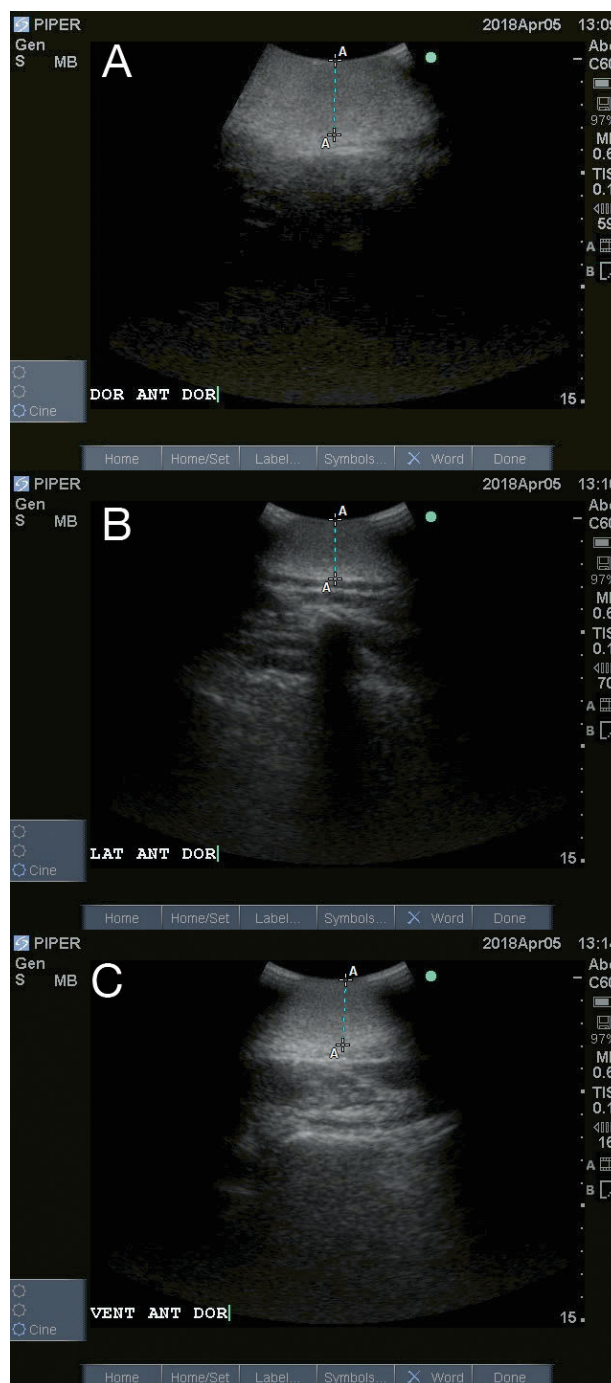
Three ultrasound images taken along the anterior dorsal fin girth location, (A) mid-dorsal (DOR ANT DOR), (B) mid-lateral (LAT ANT DOR) and (C) mid-ventral (VENT ANT DOR), for an adult female pilot whale during one of the sample intervals. Blue dashed line represents blubber thickness
